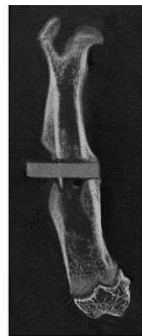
A μ CT image (ID: 2644) taken 2 weeks postoperative reveals minor damage to the bone, likely incurred during the implantation procedure.
